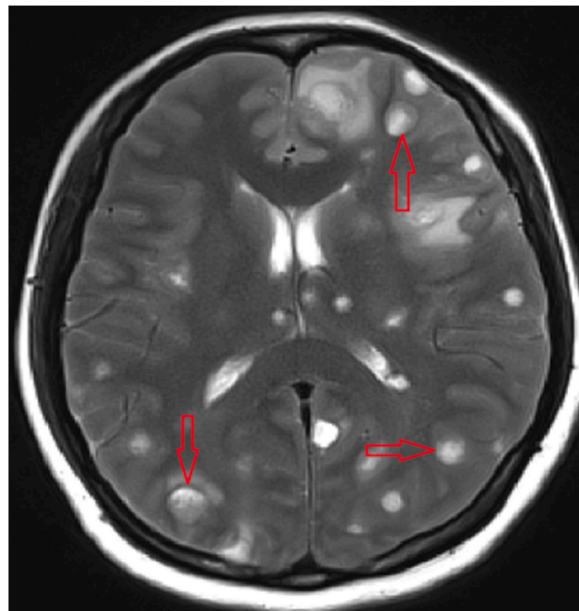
Brain MRI suggested cerebral metastases (May 2022).
